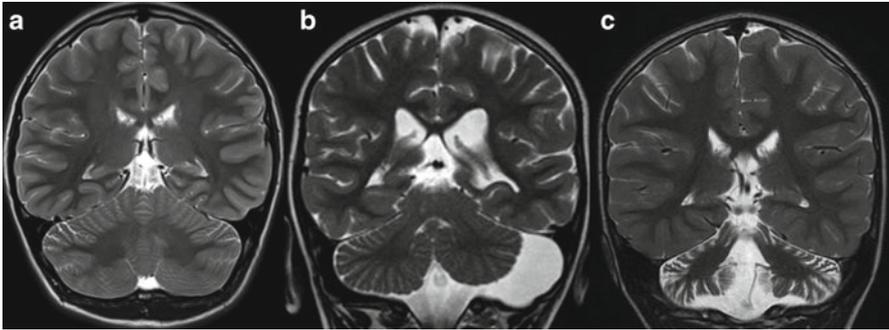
Coronal T2-weighted images in three children with non-progressive cerebellar ataxia (NPCA) show normal cerebellar findings in (a), cerebellar hypoplasia involving mostly the left hemisphere in (b), and enlarged interfolial spaces remembering cerebellar atrophy, but static course in (c)
